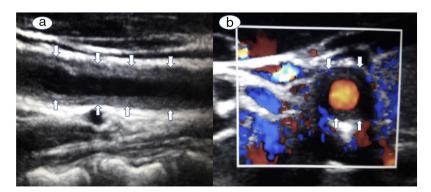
Ultrasound B mode scanning of the right carotid artery on longitudinal [a] and transverse [b] cuts, showed homogenous, mid-echoic, circumferential wall thickening.
